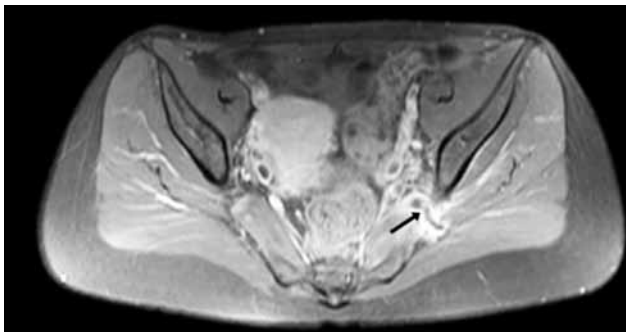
Axial FS-T₁ weighted hip magnetic resonance imaging with contrast showing left inferior gluteal vein thrombosis (black arrow).
